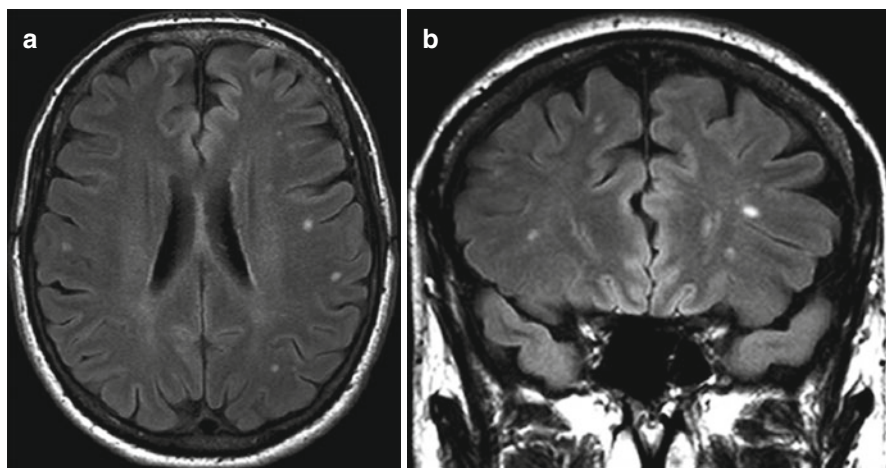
Axial (a) and coronal (b) fluid-attenuated inversion recovery magnetic resonance images of the brain from a 61-year-old patient with migraine without aura. Multiple hyperintense, small, punctuate lesions are visible in the deep and juxtacortical white matter
